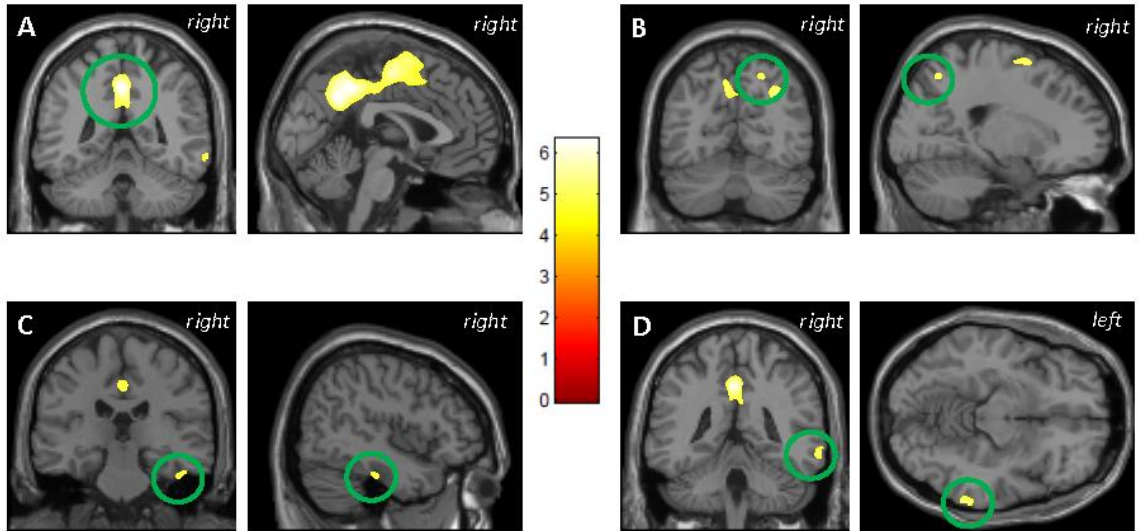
VBM analysis of MRI and plasma NFL in amyloid positive participants.
